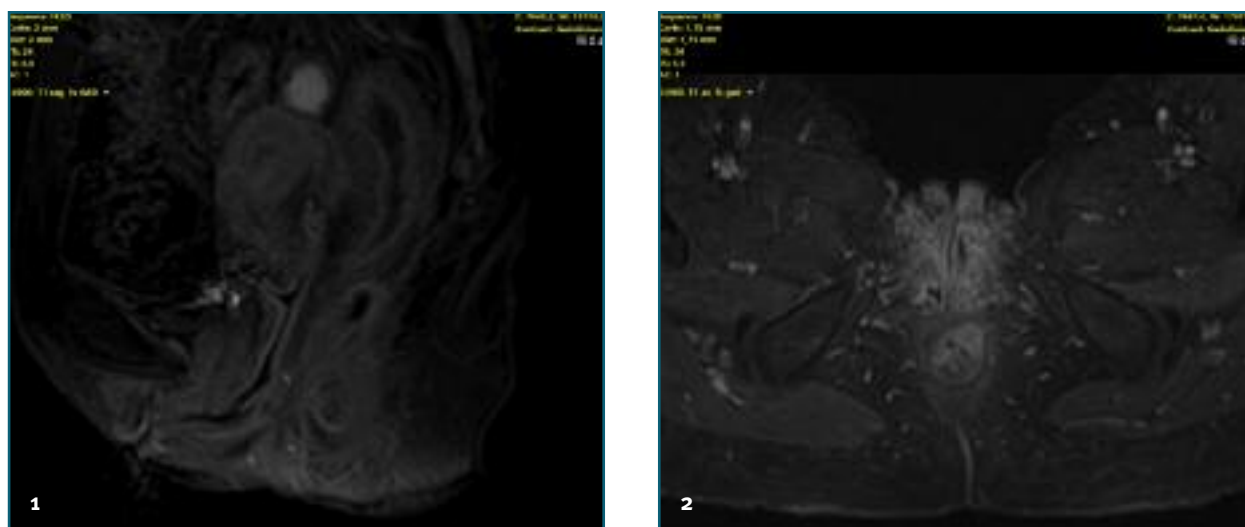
Images from sagittal (1) and axial (2) Fat Suppressed Contrast-Enhanced T1-weighted pelvic magnetic resonance imaging indicating transsphincteric fistulization involving the labia majora (arrows).
